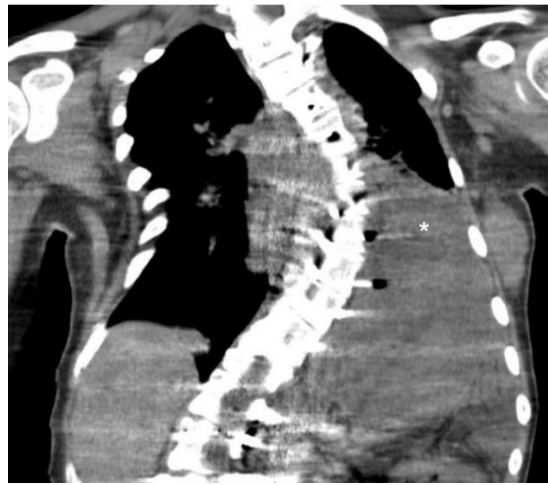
Thoracic CT Scan: Elevation of Left Diaphragmatic Muscle (*).
